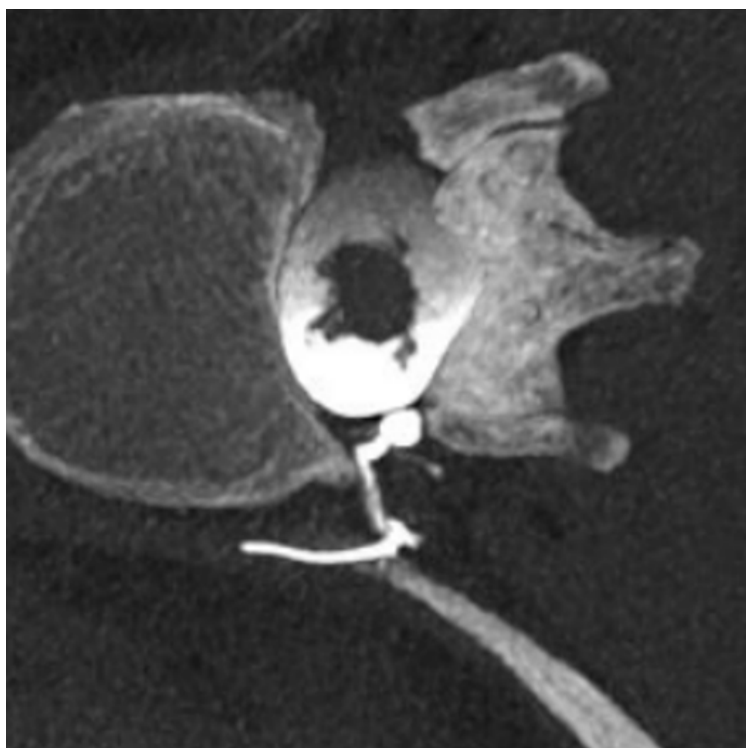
Axial maximum intensity projection (MIP) image of a decubitus CT myelography in the right lateral decubitus position showing a CSF-venous fistula on the right T10-T11 level, with opacification of intervertebral and paraspinal veins.
